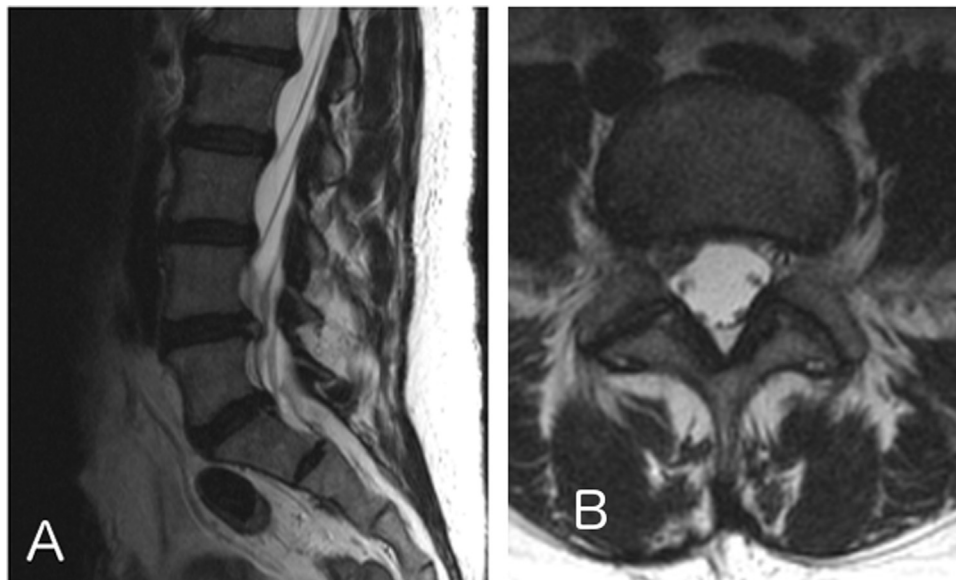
A 40-year-old female with persistent L5 radiculopathy. Sagittal (A) and axial (B) T2 MRI images, demonstrating a right posterolateral L4/5 herniated disc
